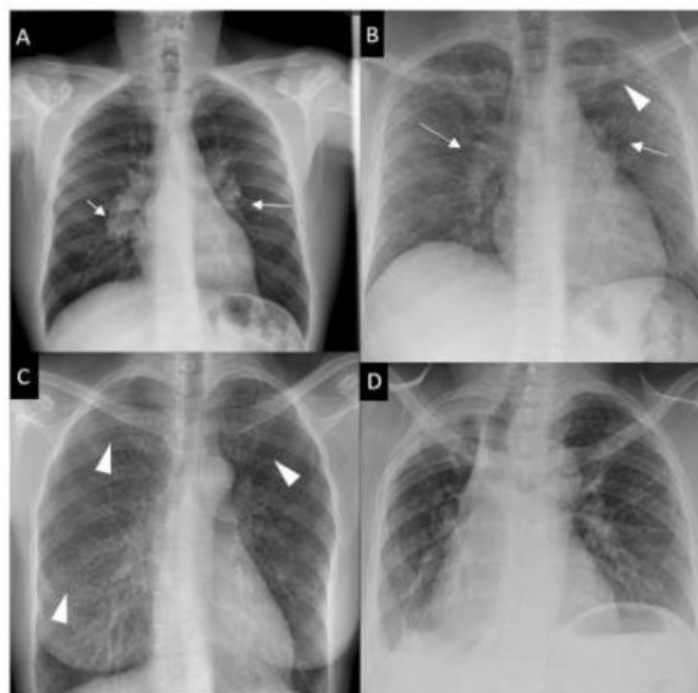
Five stages of sarcoidosis can be recognized using Scadding's classification on Chest x-rays(CXR). Stage 0, which is not shown, represents a normal X-ray, Stage 1 features bilateral hilar lymphadenopathy (A); Stage 2 features bilateral hilar lymphadenopathy and pulmonary infiltrates in upper lobes (B); Stage 3 features pulmonary infiltrates without bilateral hilar lymphadenopathy (C); and Stage 4 is pulmonary fibrosis (D). *Source: Sève, P. et al. Sarcoidosis: A clinical overview from symptoms to diagnosis. Cells 10, (2021).*¹⁶
